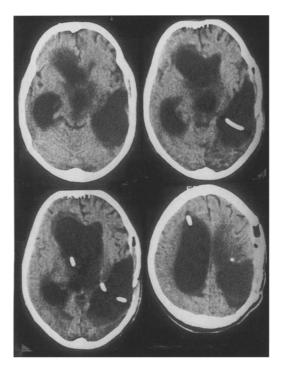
CT-scans of an 11 year old Libyan girl with drainage catheters of both enlarged cerebral ventricles and a right temporo-parietal hydatidous cyst.
